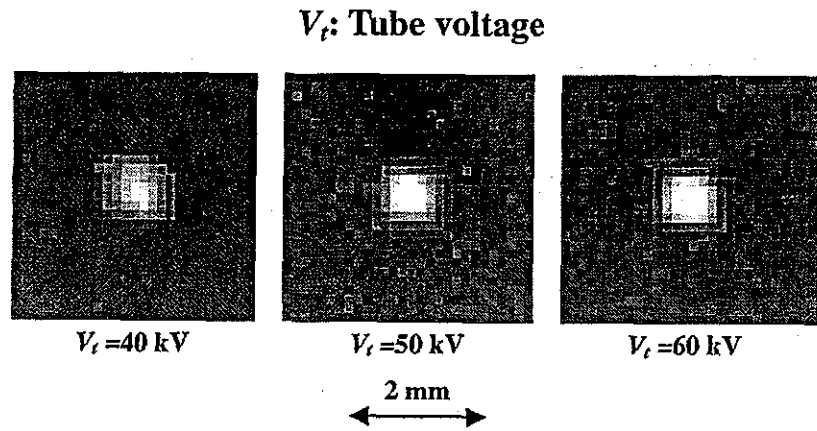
Images of the X-ray source measured by a 100 mm diameter pinhole with changes in the tube voltage.
